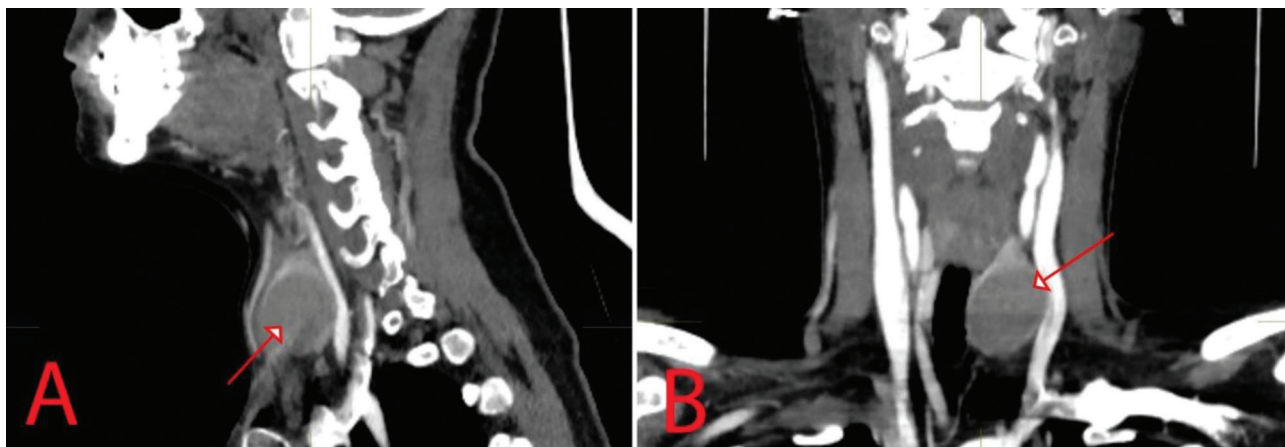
CT of the thyroid mass. A. Sagittal CT (arrow indicates the thyroid cyst); B. Frontal CT (arrow indicates the thyroid cyst).
